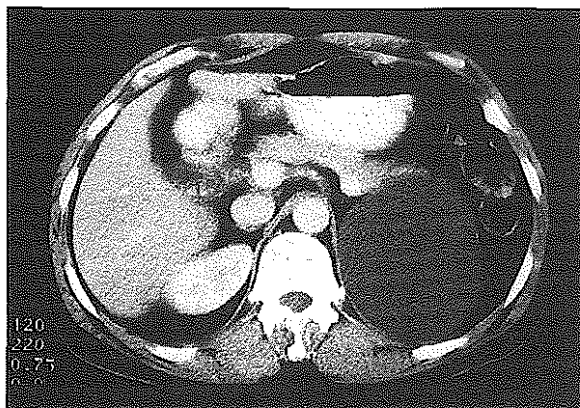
CT Scan showing a 10 x 10cm smooth walled cyst in left adrenal gland with speck of marginal calcification.
